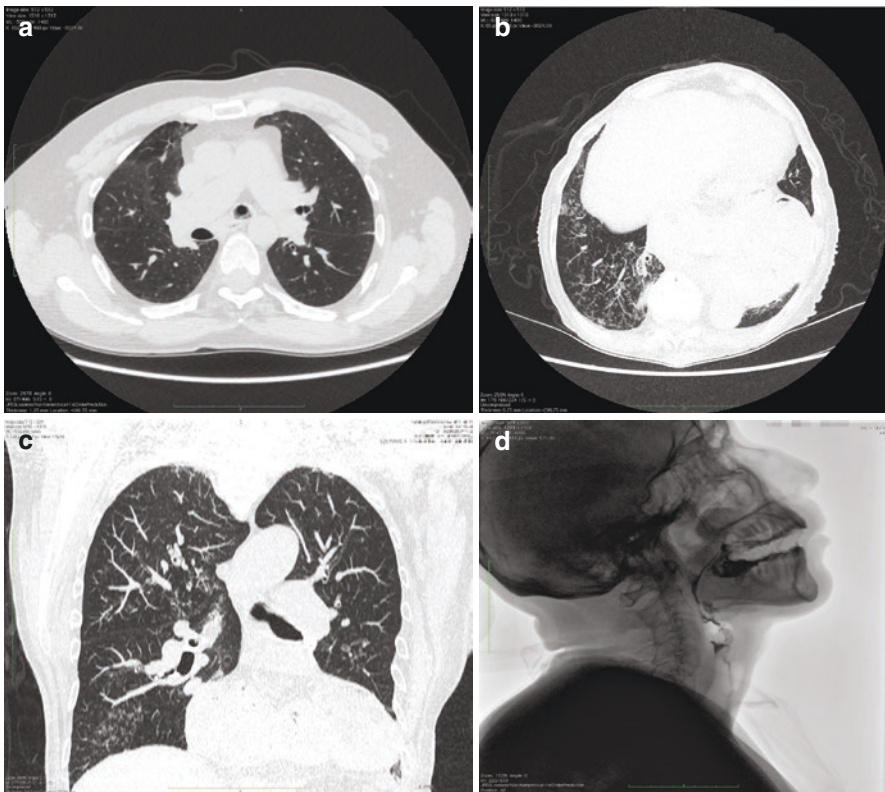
Hiatal hernia, GERD, and diffuse aspiration bronchiolitis (DAB) in a 58-year-old woman with fever. HRCT chest axial images (a, b) and coronal reconstruction (c) show a large hiatal hernia in (b) and diffuse lobular bronchioles dilatation filled by mucus and pus (tree-in-bud pattern). This pattern is a known manifestation of various entities as aspiration of infected oral secretions or other irritant material into small airways. (d) VFSS lateral view shows associated tracheal aspiration
